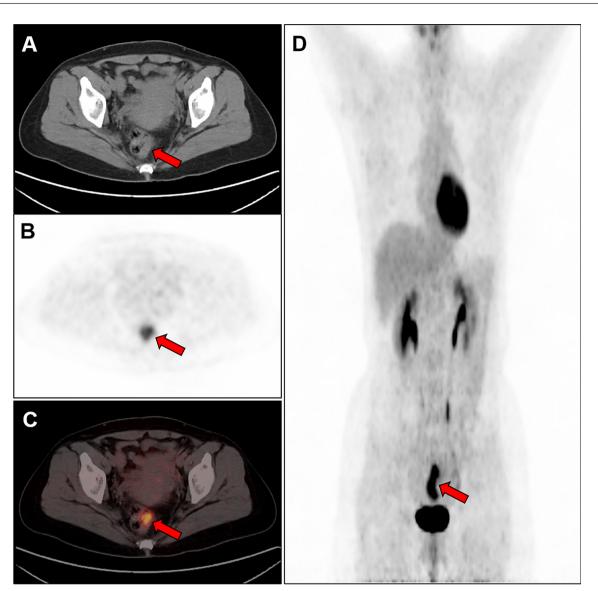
Representative PET/CT images. A 49-year-old female patient with HER2-negative rectal cancer: A) CT scan; B–D) the primary tumor had a lower radio-uptake SUVmax = 9.1
